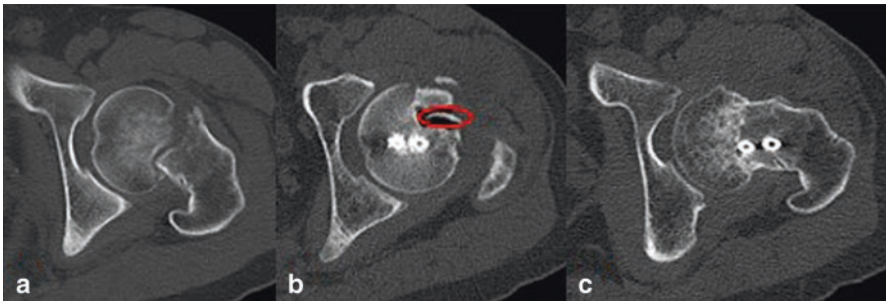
(a) Preoperative CT showing Garden III fracture; (b) postoperative CT showing magnesium screw (red ring) and two cannulated screws; (c) 12 months postoperative CT showing the fracture healing [116]
